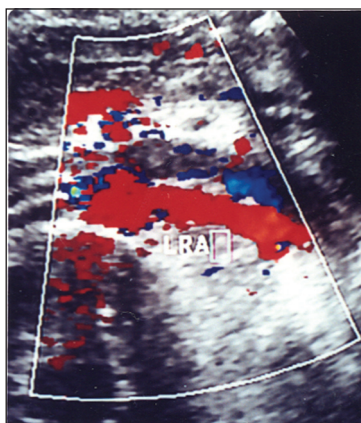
24 year-old man with nephrotic syndrome and left vein thrombosis. Color Doppler ultrasound image revealed echogenic thrombus in the left renal vein and absence of flow. Normal left artery seen below the thrombosed vein.
